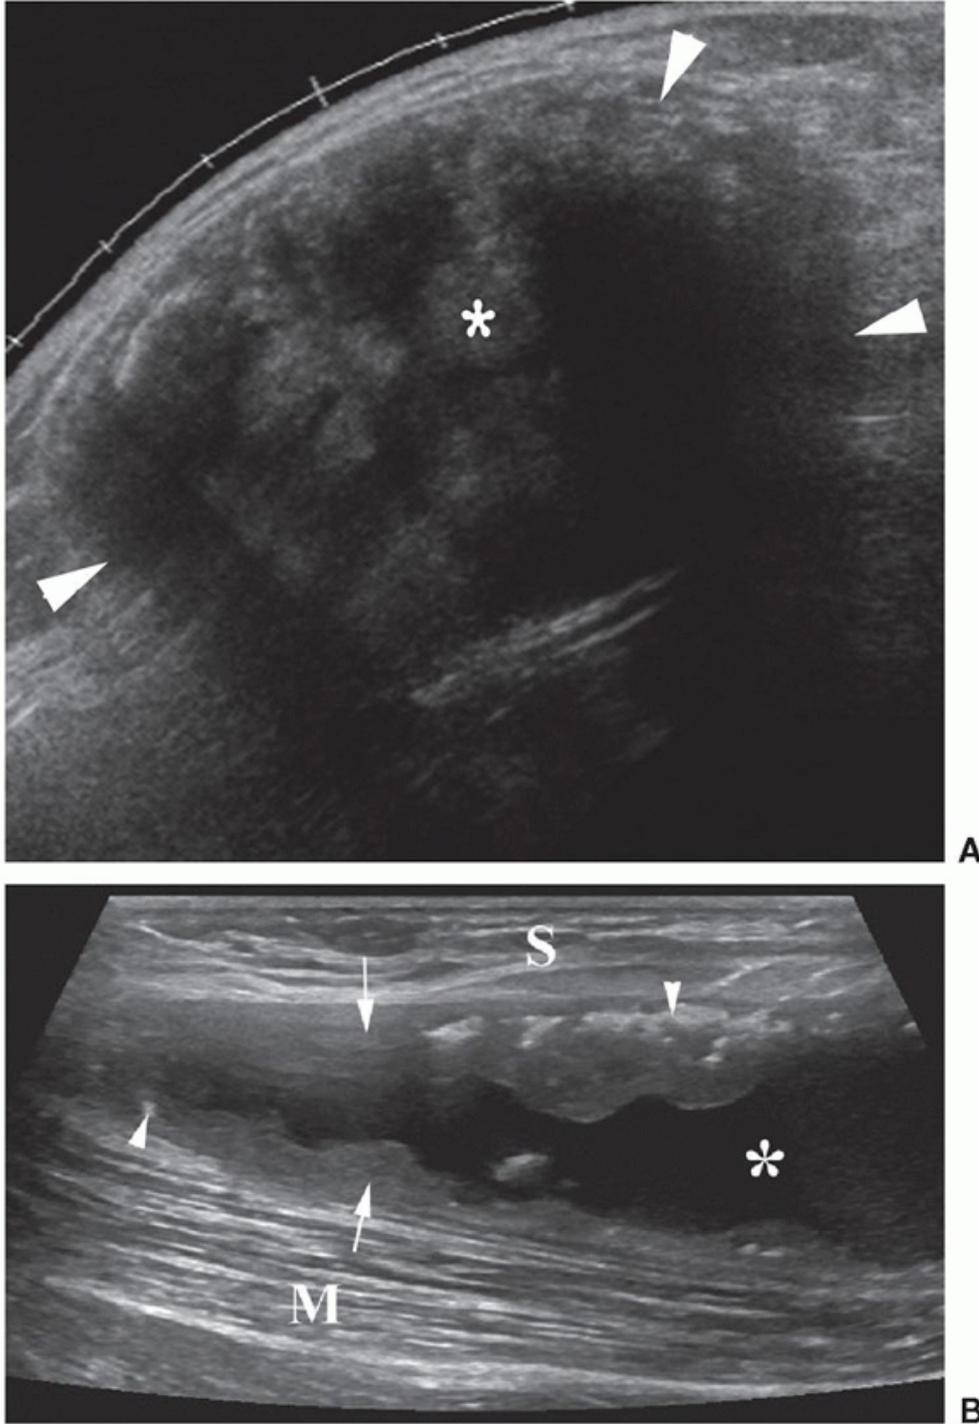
Morel-Lavallee lesions. A: Longitudinal sonogram shows large predominantly hypoechoic lesion (arrowheads) with lobules of echogenic fat (asterisk). B: Longitudinal sonogram shows chronic lesion forming after documented trauma 4 years previously with thick-walled pseudocapsule (arrows) containing echogenic particles (arrowheads) between the muscle (M) and subcutaneous fat (S) layers. The fluid (asterisk) had accumulated, causing apparent growth.
